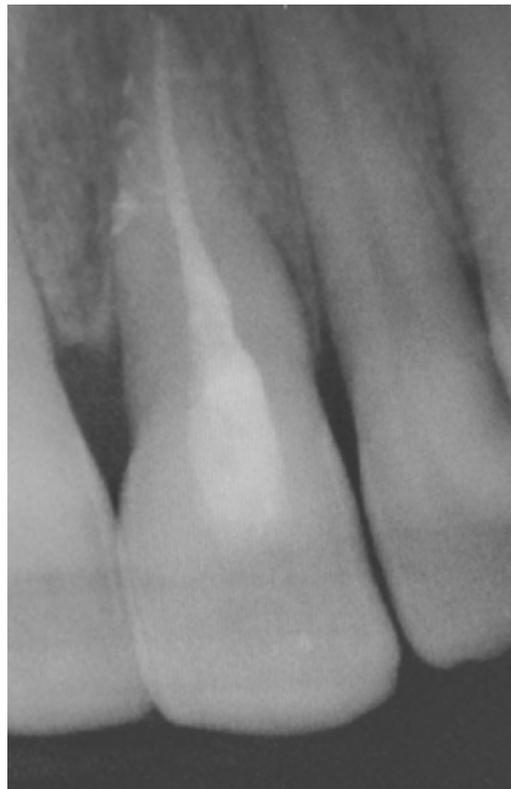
Post-operative radiograph of 2.1. Obturation with thermo-plasticized guttapercha after activation and heating of irrigants: several lateral canals are shown.
